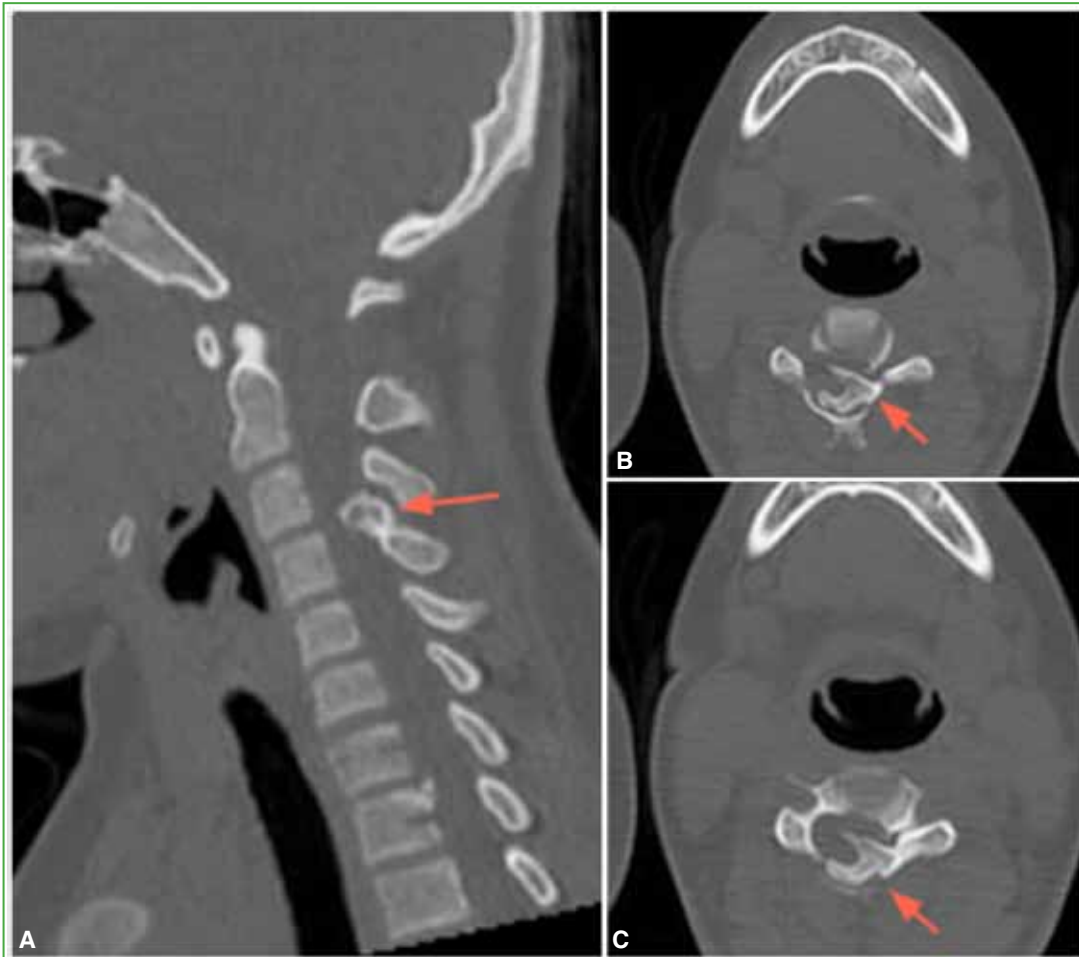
Computed tomography of the cervical spine, sagittal (A) and axial (B and C) sections. Osteochondroma of the left lamina of C4 with narrowing of the spinal canal (red arrow).
